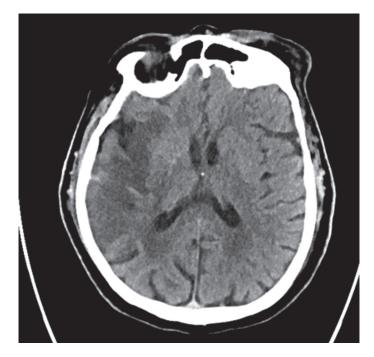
CT of the brain, axial section, view of ischemic stroke. Source: CHC Rijeka database (retrieved June 30, 2021)
